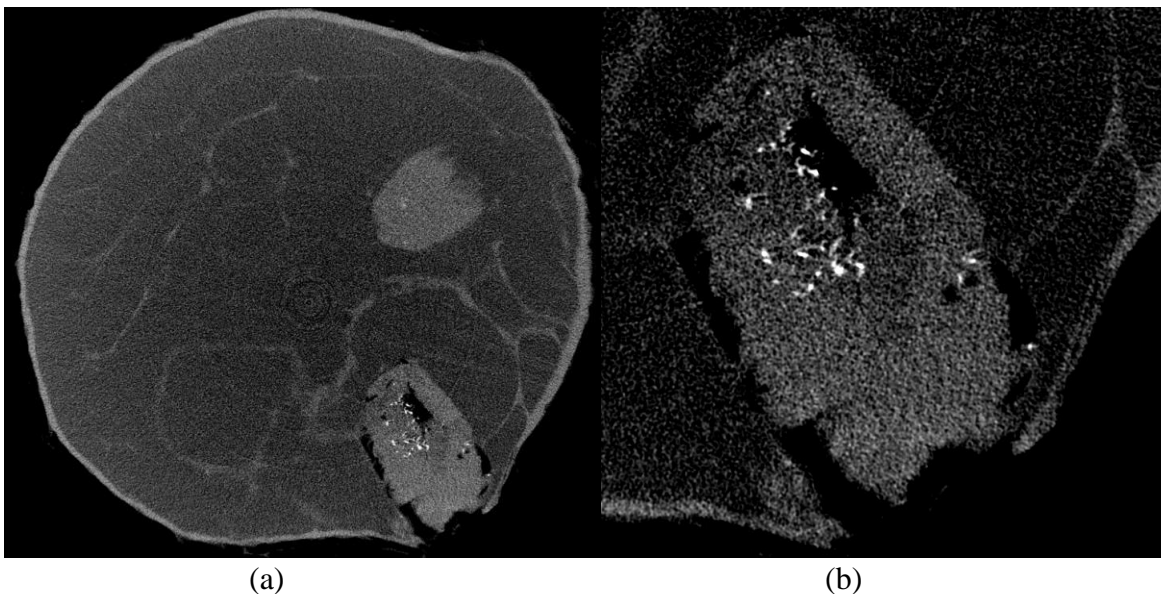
(a). The reconstructed CT image of the postmortem breast at 12 mGy with microcalcification inserts. (b). The extracts of (a) with 250 μm calcification.
